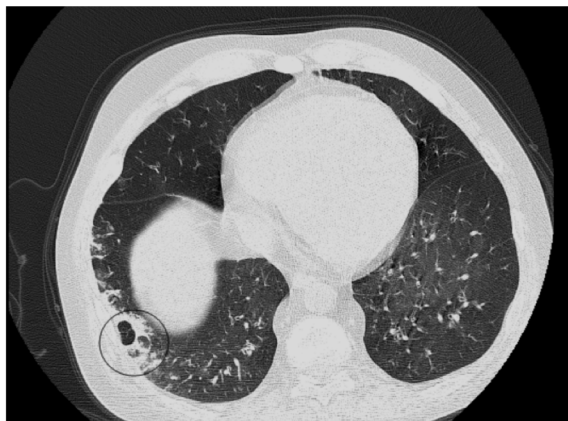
Male patient aged 48 years. Non contrast chest CT after 17 days of the mild clinical course of COVID-19 infection shows CT findings consistent with CORADS 5 category and CT severity score (5). Axial cuts at the same level in lung a sub-segmental area of consolidative changes located peripherally associated with cavity formation is seen at the right lower lung lobe (circles). No ventilation needed and discharge was decided after 14 days of isolation.
